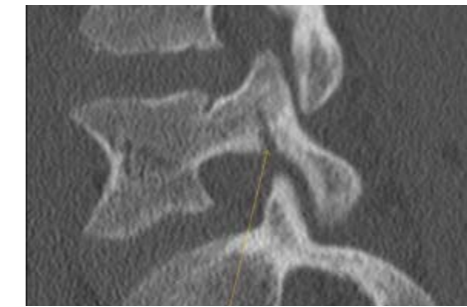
CT sagittal reformat. Incomplete L5 pars stress fracture.
